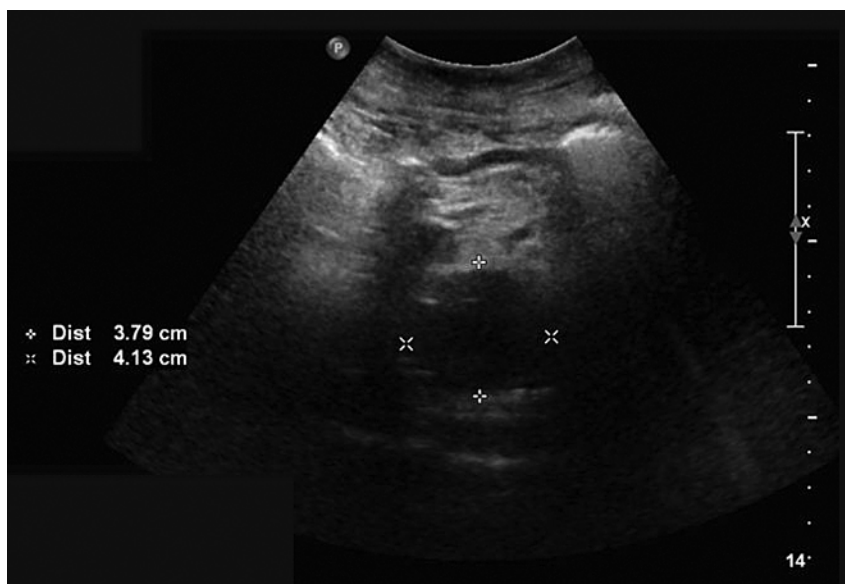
Surveillance ultrasound image of a small (4.13 cm diameter) infrarenal abdominal aortic aneurysm.
